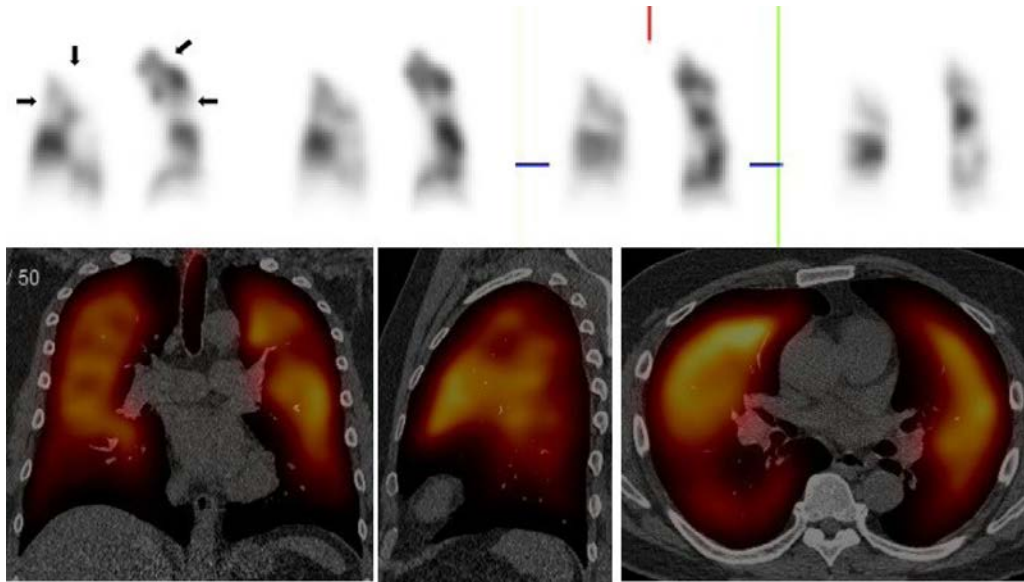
VQ-SPECT CT in a 38 year old male with CTEPH. Coronal perfusion views from the SPECT series (Top) demonstrates multiple segmental perfusion defects in both lungs (black arrows). Coronal, sagittal and axial reconstructions (Bottom) delineates the perfusion component overlaid on the axial low dose CT. The addition of CT to SPECT improves the specificity of the VQ by promoting the identification of lung diseases. CTEPH, Chronic thromboembolic pulmonary hypertension. VQ, ventilation-perfusion.
